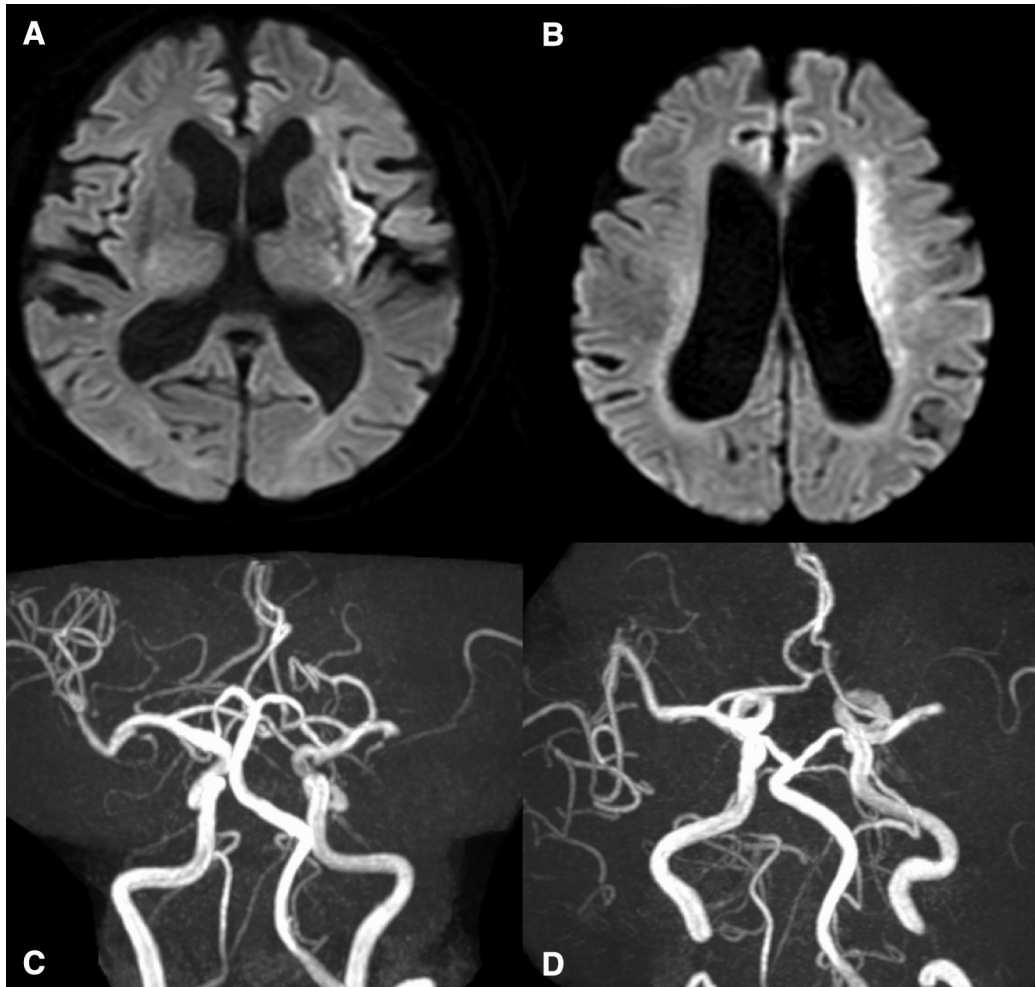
(A and B) Initial DWI after arrival to our hospital shows acute ischemic change in the left insula and corona radiata. (C and D) MRA shows left M1 occlusion. DWI: Diffusion-weighted image
